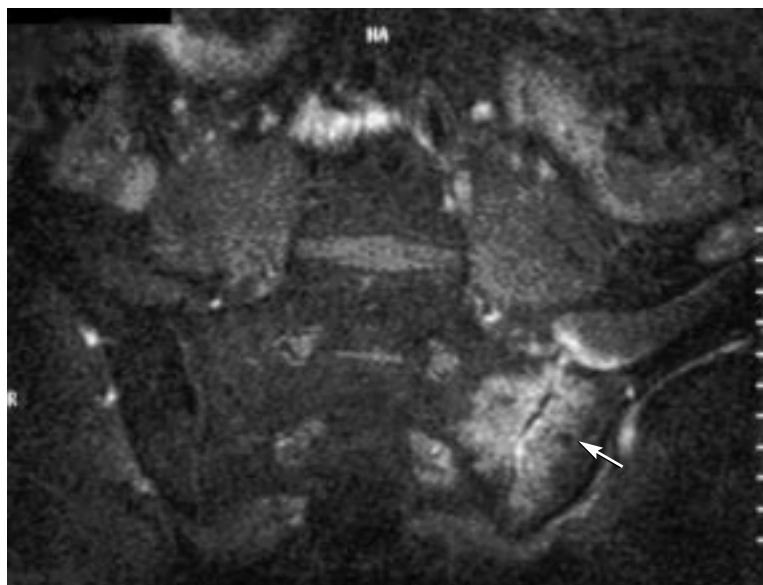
Magnetic resonance image of the pelvis showing areas of edema and soft-tissue swelling around the sacroiliac joint (arrow), with increased uptake consistent with infection.
